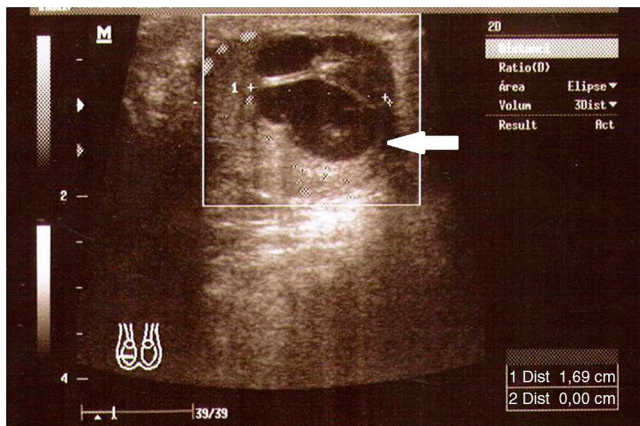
Ultrasound scan of the right testicle which shows a cystic fine-tissued tumor with irregular hypoechoic areas.
